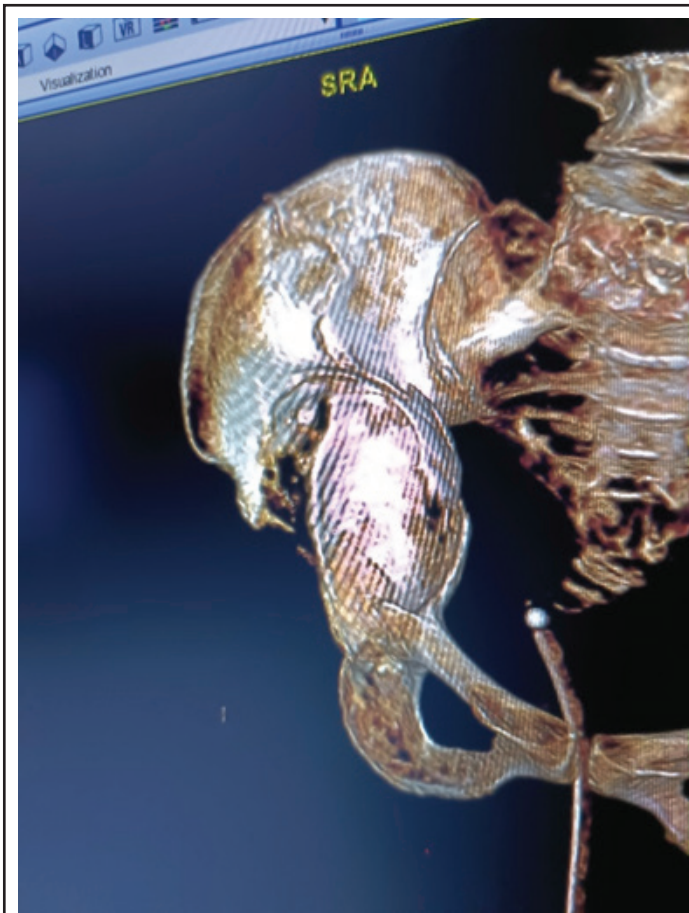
CT 3D images provides virtual images of the extent of bone destruction.
